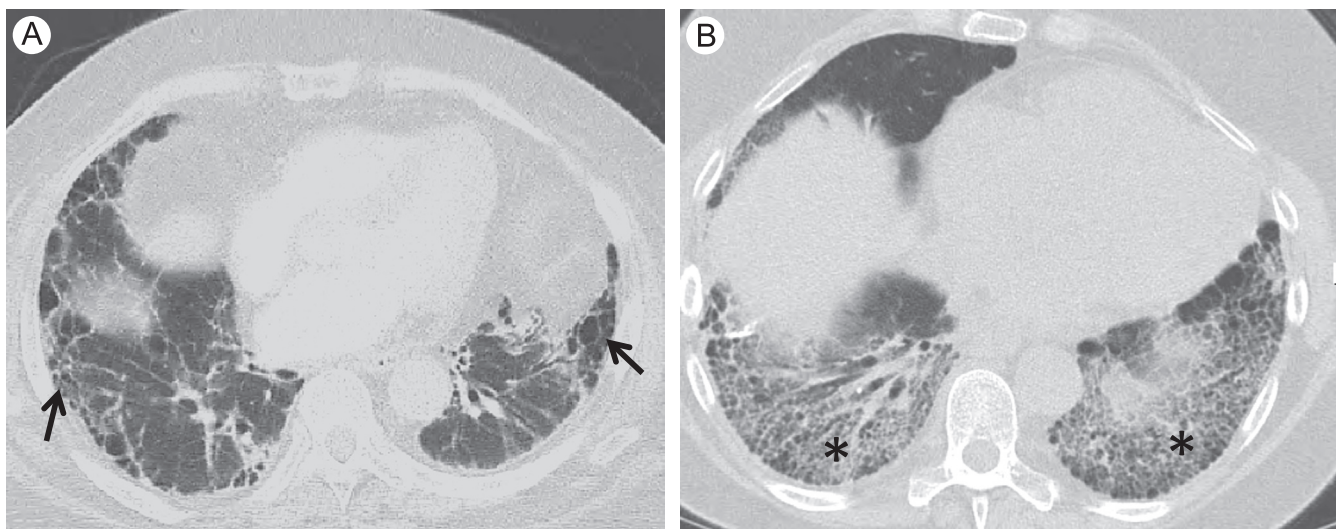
Rheumatoid arthritis. (A) High-resolution CT (HRCT) image from an 81-year-old woman with rheumatoid arthritis (RA) and usual interstitial pneumonia (UIP) on biopsy. Note the peripheral and basilar predominant honeycombing with irregular septal line thickening, traction bronchiectasis, and a relative paucity of ground glass (arrows). (B) HRCT image from a 65-year-old woman with RA and fibrotic nonspecific interstitial pneumonitis (NSIP) on biopsy. Note that there is less honeycombing and more ground glass (*) as compared with (A).
